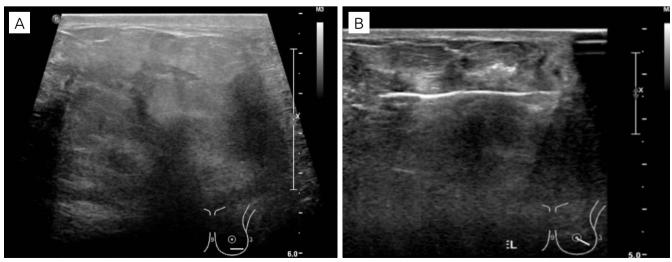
Ultrasound (A) with skin edema and enhancement with parenchymal hyperechogenicity; (B) core biopsy.
